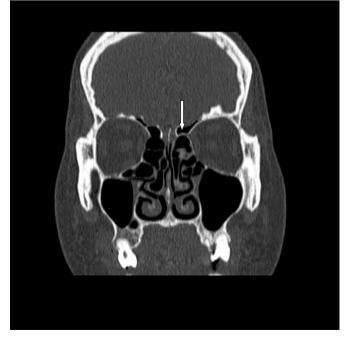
Coronal computed tomography image. A suspended band between the cribriform plate and lamina papyracea is characteristic of a mesenteric type of anterior ethmoid artery.
